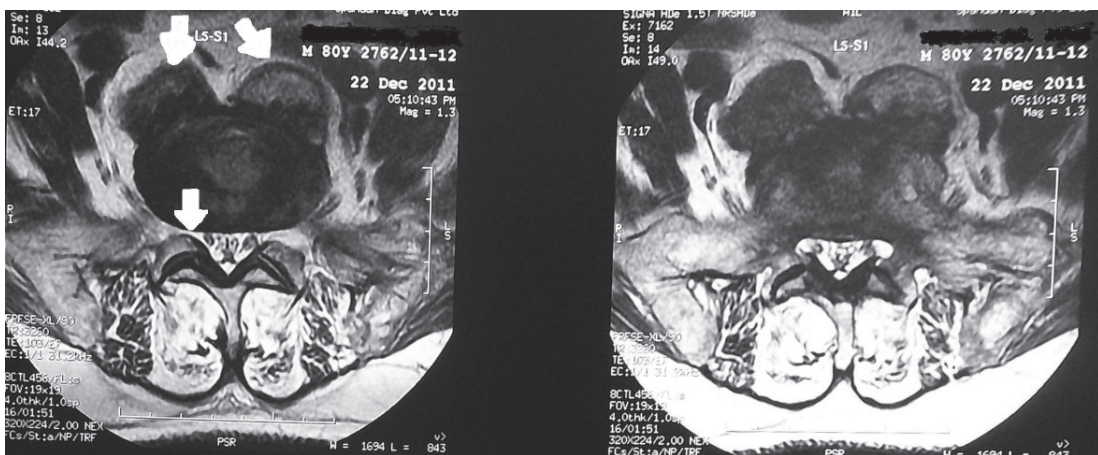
MRI (T2W) L-S spine axial view. Arrows show narrowing of neural foramen on right side and calcification of anterior longitudinal ligament.
